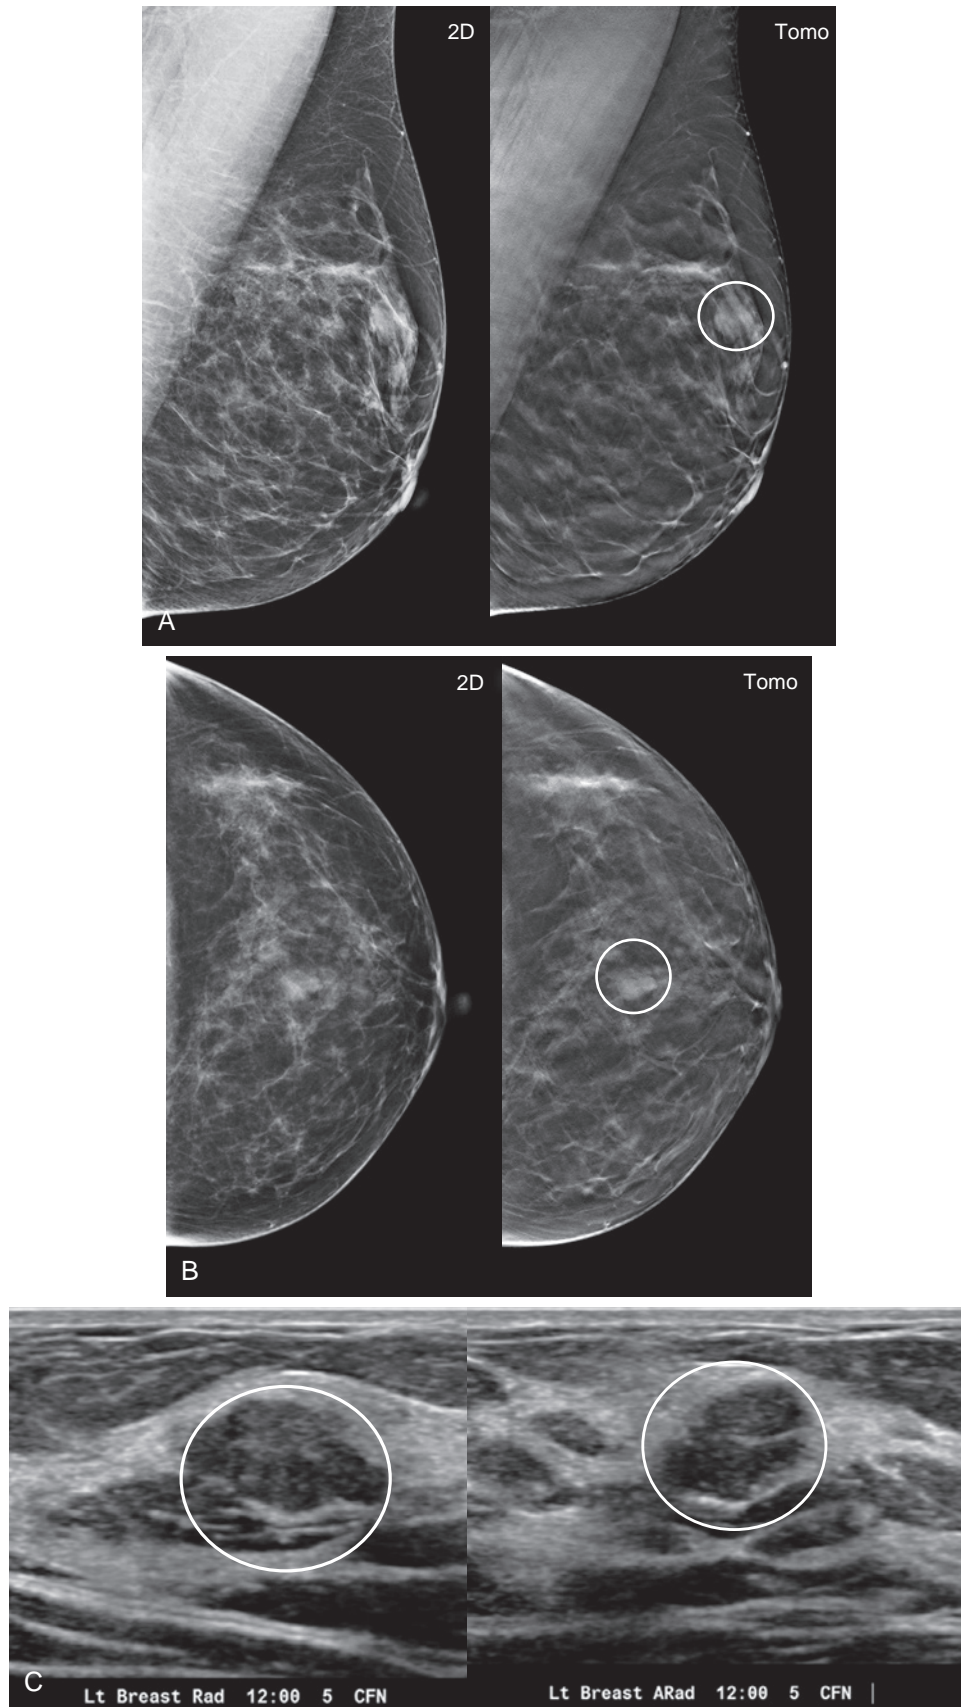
Benign mass. Baseline mammogram in a 40-year-old woman. (A) Mediolateral oblique and (B) craniocaudal views in 2D imaging and tomosynthesis demonstrate a mass in the left breast at the 12-o'clock position (*circled*). (C) Targeted ultrasound images demonstrate a corresponding hypoechoic mass (*circles*). The mass was unchanged at 1-year follow-up and presumably represents a fibroadenoma.
